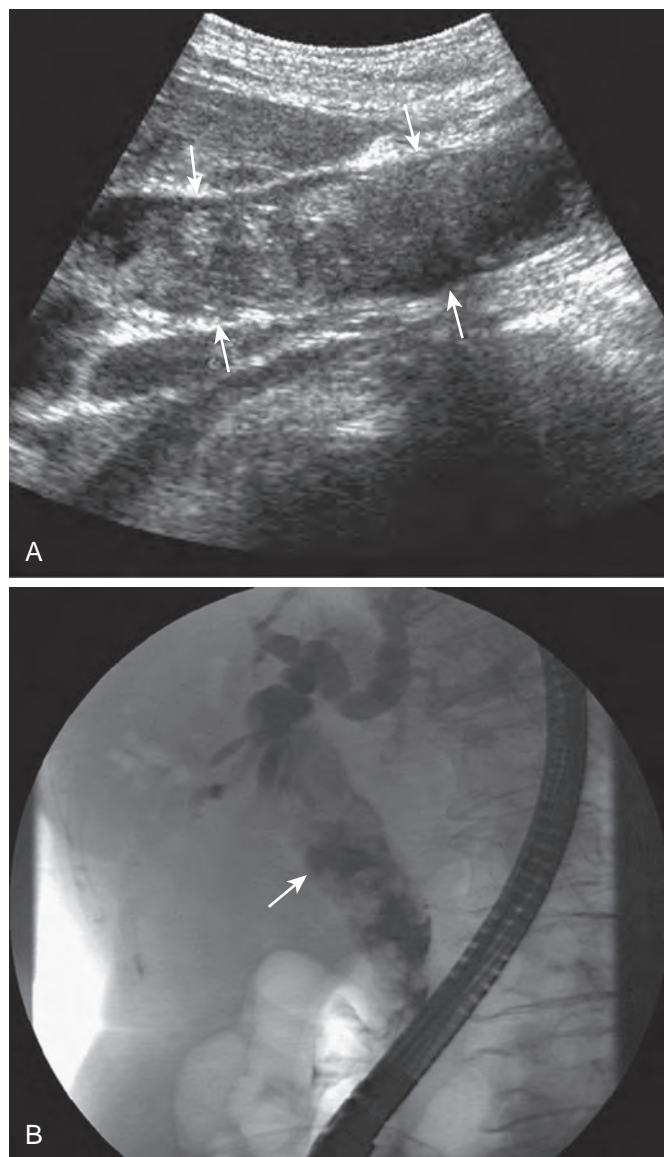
Ascending obstructive cholangitis. A. Sagittal sonogram shows a markedly dilated common bile duct (arrows) filled with sludge and stones. B. ERCP shows a dilated intrahepatic and extrahepatic biliary system with multiple filling defects (arrow). The patient recovered after urgent papillotomy and administration of antibiotics and intravenous fluids. (From Hanbidge AE, Buckler PM, O'Malley ME, et al: Imaging evaluation for acute pain in the upper abdomen. *RadioGraphics* 24:1117–1135, 2004.)
